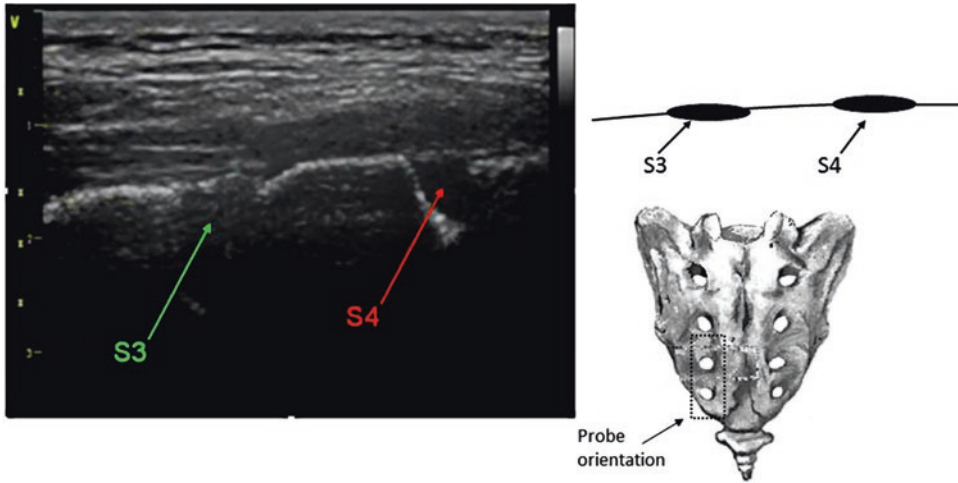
Ultrasound view of landmarks. In the sagittal view, the S3 and S4 foramen can be visualized in the same image. Reprinted with the permission of Medtronic, Inc. © 2017
